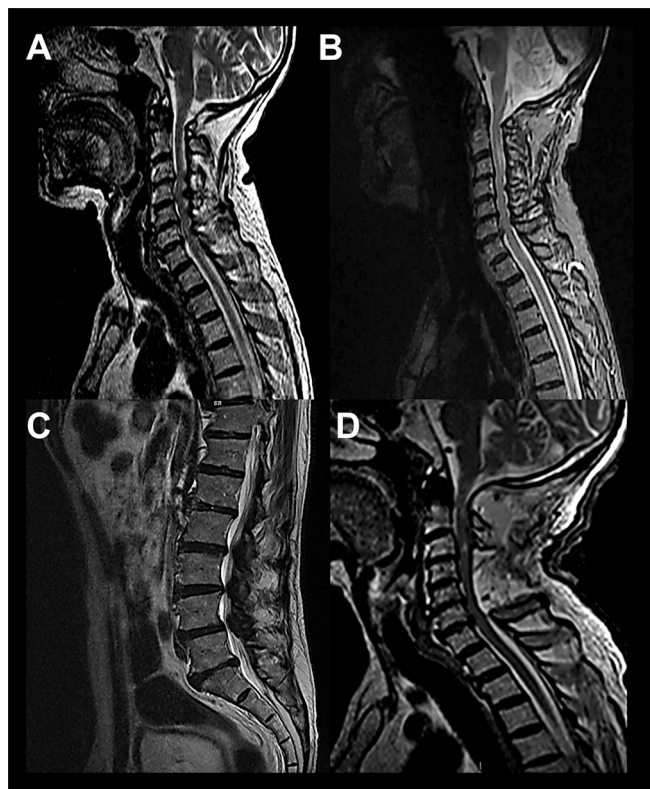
MRI of the spinal cord demonstrating cervical spondylotic myelopathy and lumbar stenosis. (A) Sagittal T2-weighted contrasted image of the cervical spinal cord showing multilevel stenoses of the cervical canal and compressions to the spinal cord. Notice the enlargement of the posterior arch of the atlas. (B) Spondylotic myelopathy is revealed by a slight intramedullary hyperintensity at C2-C3 segments. (C) Sagittal T2-weighted contrasted image of the lumbar spine showing data of multilevel lumbar stenosis. (D) Postoperative sagittal T2-weighted MRI of the cervical spinal cord demonstrating decompression of the cervical canal.
